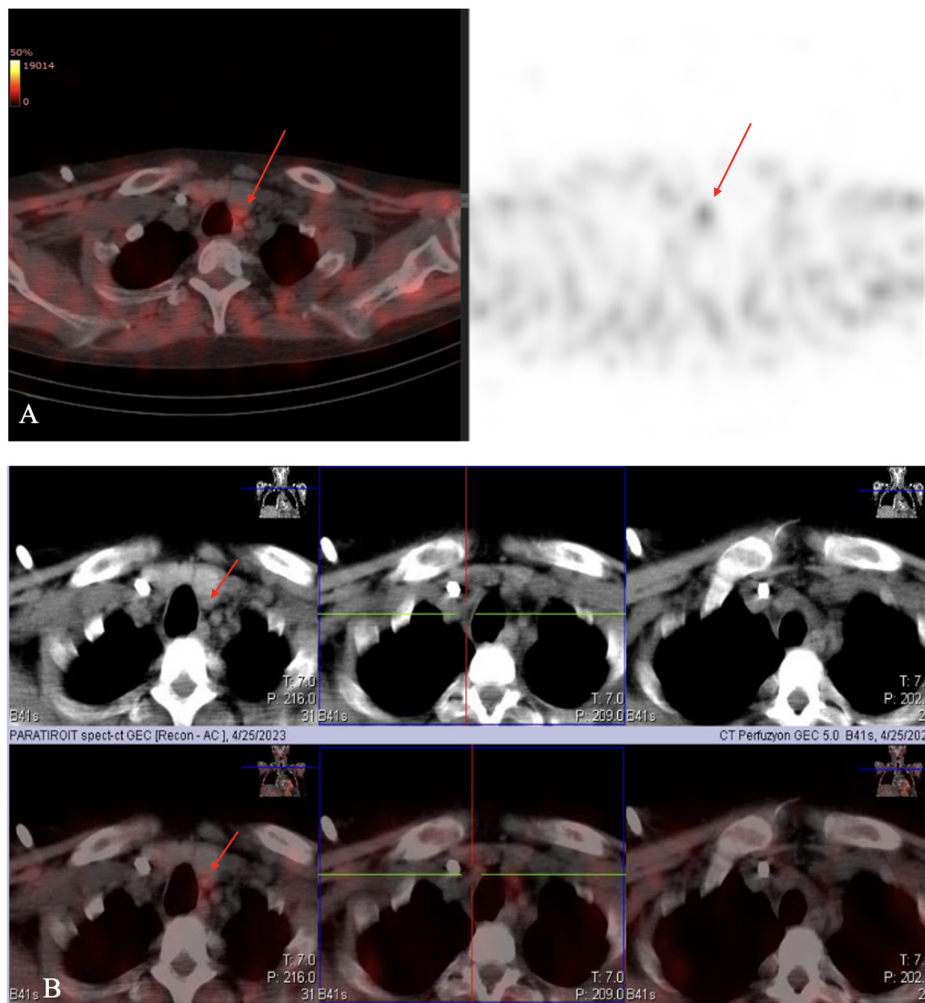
(A, B) Parathyroid scintigraphy showing minimal uptake in a millimetric focus located in the posterior lower pole of the left thyroid lobe, which exhibited no washout in the late images.
